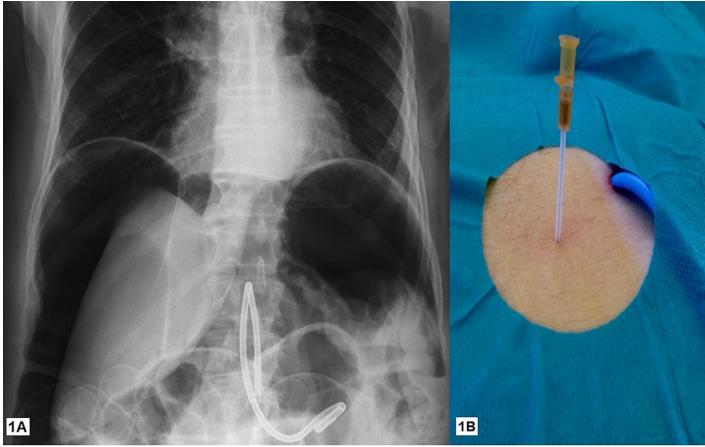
A. Chest-abdominal x-rays showing a giant pneumoperitoneum. B. Percutaneous drainage of the pneumoperitoneum on the right flank using a 16G IV catheter.
